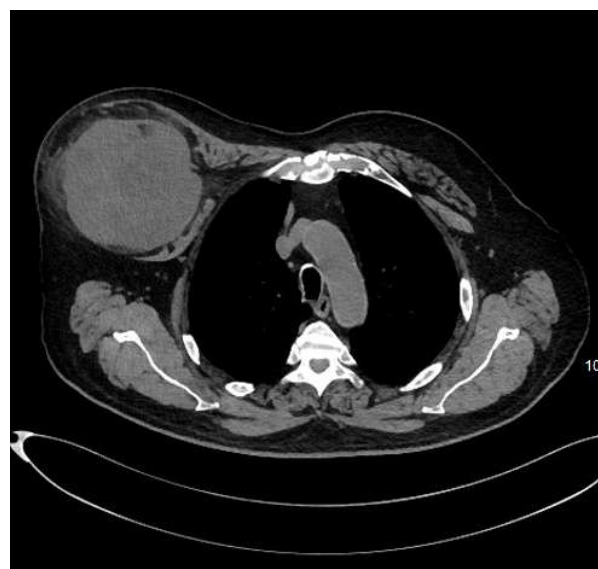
CT scan showing a 16.3x13.2x11.6 cm sized well defined large mas with fat and nodular soft tissue component in right chest wall between pectoralis major and minor muscle.
